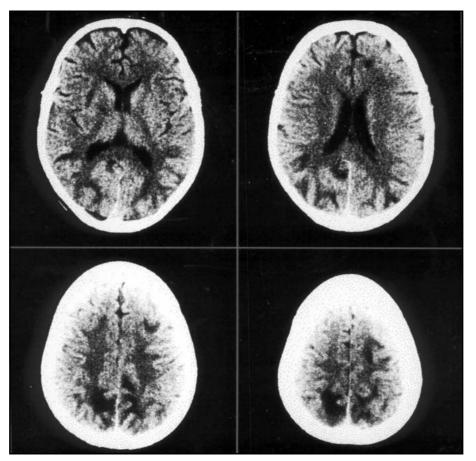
Brain CT of Patient 2 shows low density lesions involving white matter and cortical areas in posterior regions of cerebral hemispheres.
